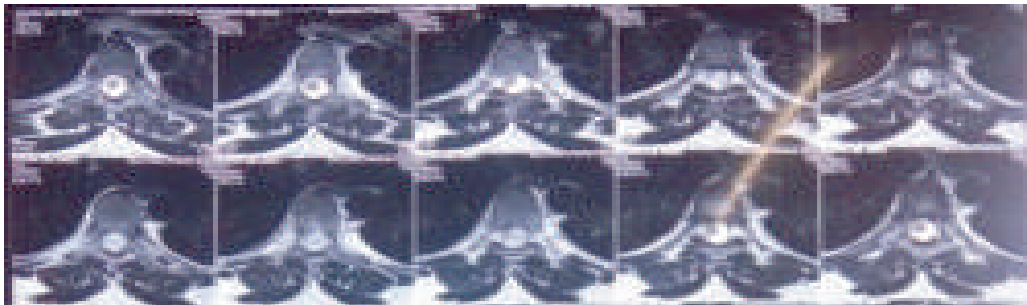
shows axial sections of T2 weighted MR image of this patient
